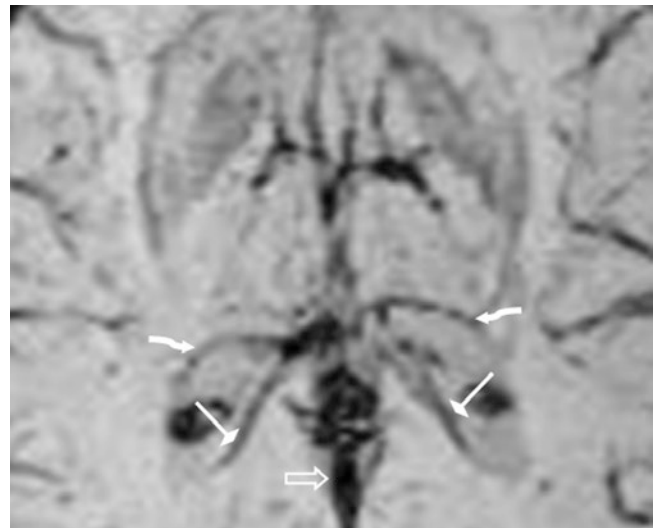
32-year-old with weakness (negative MRI). A 1.5 T 15 mm thickness SWI shows the DLVs (*curved arrows*) and the MAVs (*diamond-tip arrows*) bilaterally, as well as the VOG (*open arrow*)
